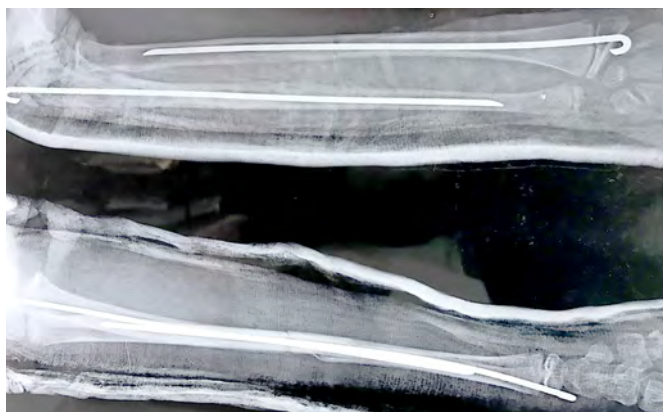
Postoperative check X-ray
